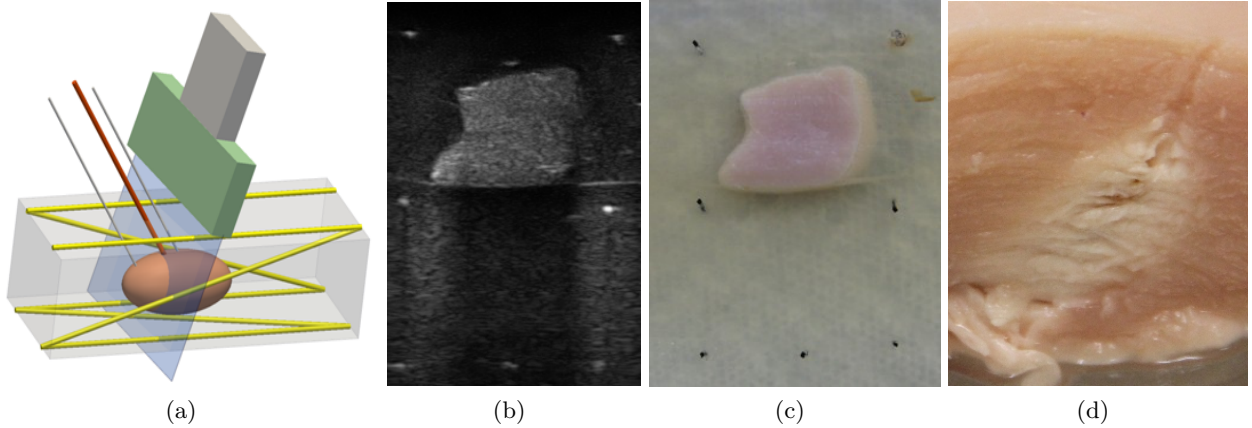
(a) The first version of the validation test-bed experimental setup. (b) An ultrasound image slice with visible fiducial lines and sample tissue. Fishing line is used as fiducial lines. (c) A pathology image slice. (d) The ablated tissue zone is clearly visible in the pathology images.
